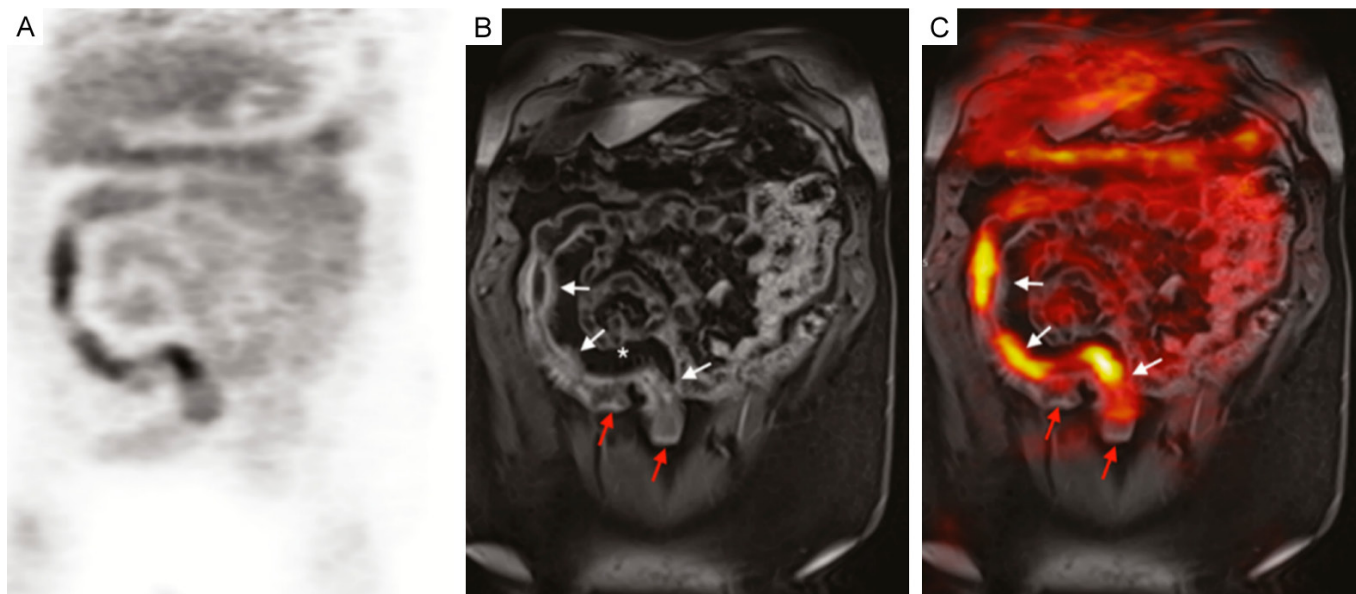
(A) 18F-FDG PET image of a patient with Crohn's disease. (B) T1-weighted MRI of the same patient. (C) Combined PET/MRI image. White arrows indicate areas of acute inflammation, while red arrows point to damage from previous disease activity. The asterisk (*) marks a site with fibrofatty tissue proliferation in the mesentery. The SUVmax for 18F-FDG ranges from 5.6 to 9.2, compared to a background bowel SUVmax of 1.5 to 2.8. Image reused from [115].
